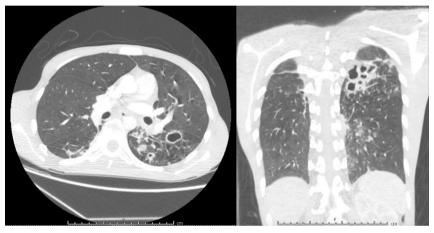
Transverse and coronal CT chest showing multiple cavitary lesions.
